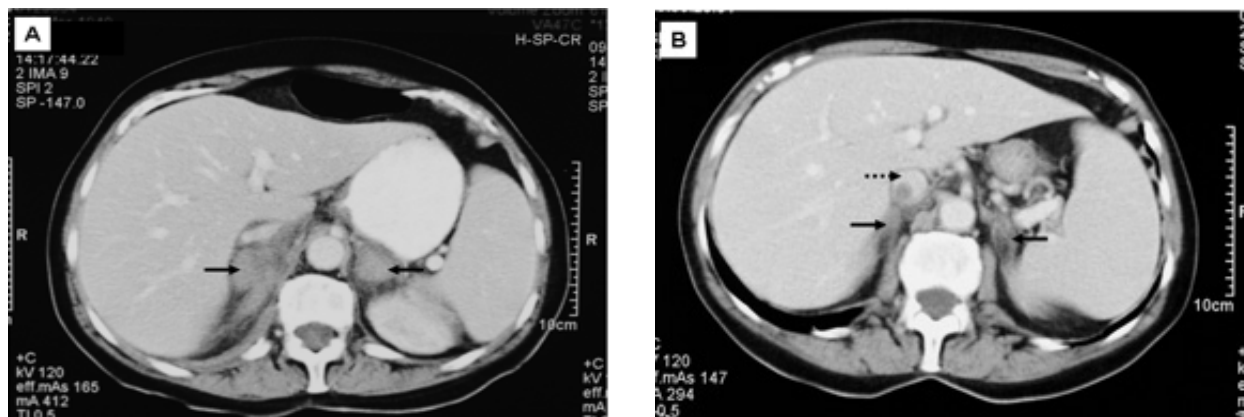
(A) CT scan at presentation showing bilateral adrenal masses (solid arrows). (B) Follow-up CT scan at 6 weeks showing a decrease in the size of the adrenal masses (solid arrows) and a thrombosis within the inferior vena cava (interrupted arrow).
